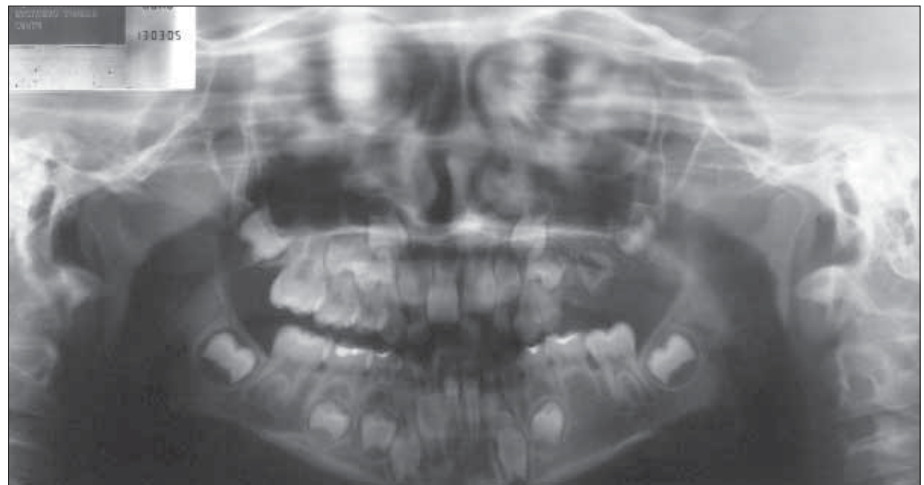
Affection of the maxillary left permanent first molar is confirmed radiographically.
